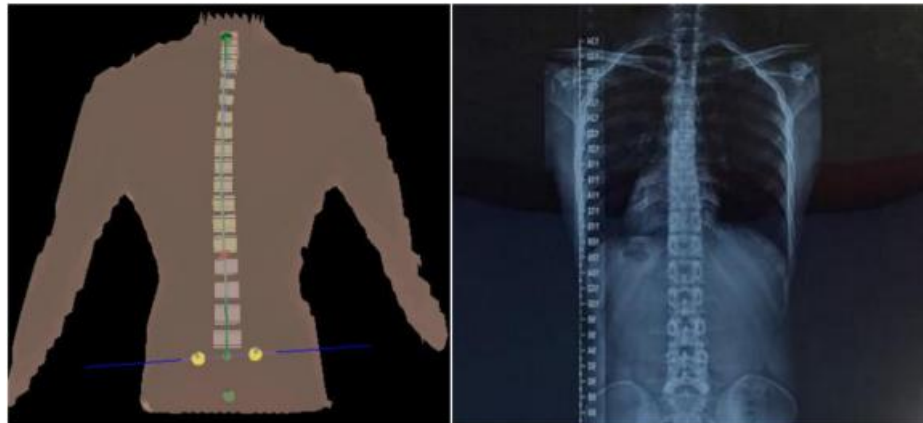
Comparative analysis of system outcomes and X-ray imaging in coronal view.
